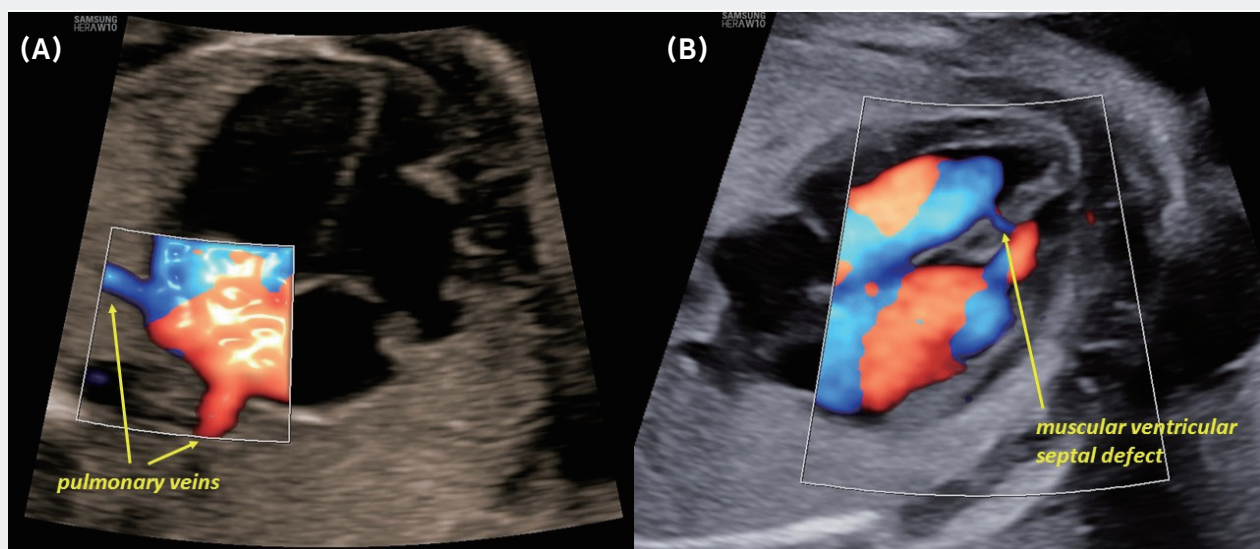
Imaging of the fetal heart with HERA W10 ultrasound system. (A) Demonstration of power Doppler imaging of the pulmonary veins draining into the left atrium in a normal case; (B) muscular ventricular septal defect imaged with power Doppler technology.
